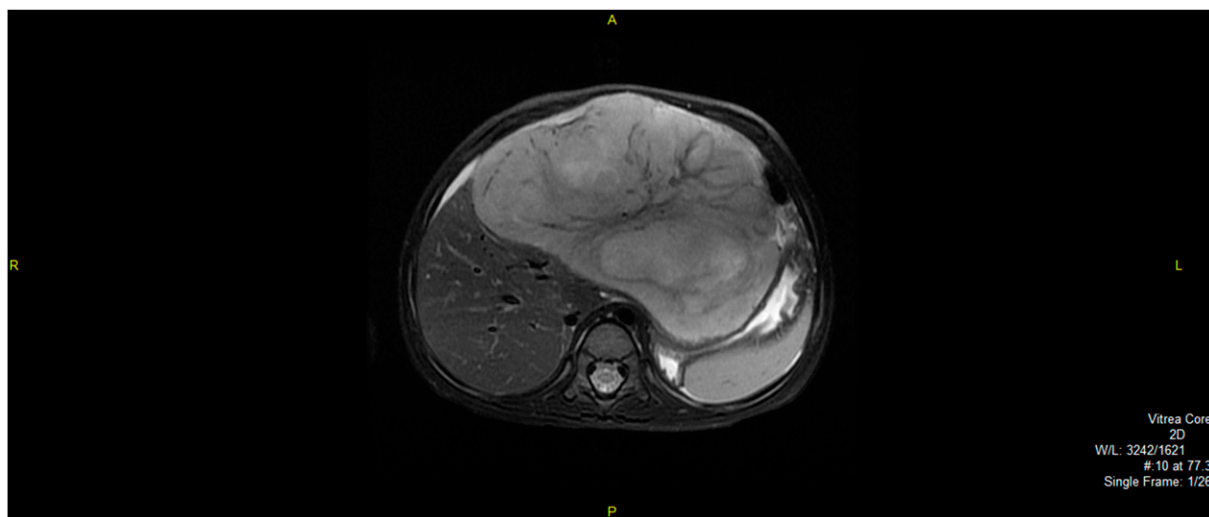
Abdominal magnetic resonance imaging shows a mass largely involving the left lobe of the liver.
